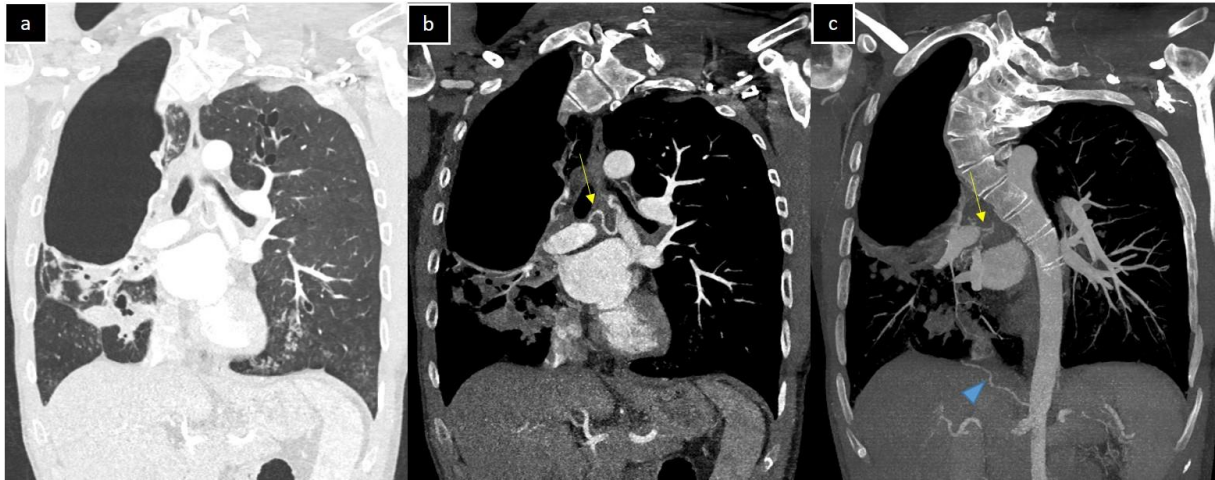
Hemoptysis in a 24 yo patient with autosomal dominant HIES and previous history of chronic cavitating aspergillosis. Coronal post contrast CT images in parenchymal (a) and mediastinal (b) windows. C: coronal oblique image with MIP post treatment. There is a large bulla occupying the right upper lobe (a), associated with enlarged bronchial (arrows) and systemic arteries (arrowhead).
